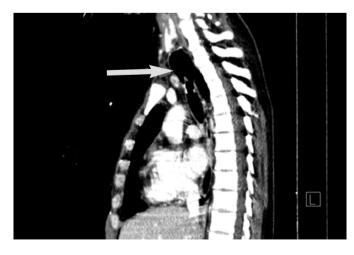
Angio-CT thoracic scan, sagital section, before the surgical intervention: Highlighting the tracheo-oesophageal fistula.
